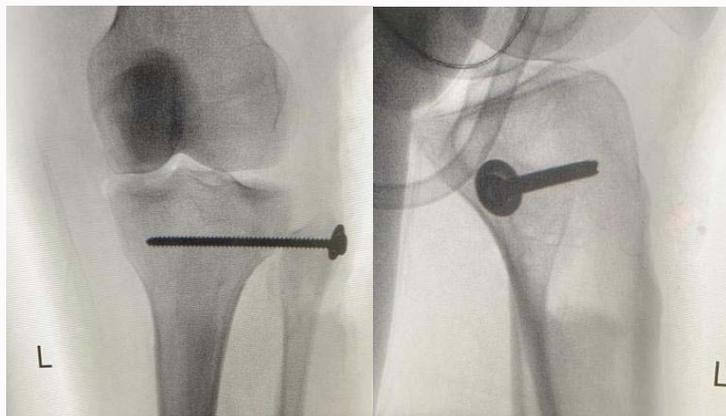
Intraoperative AP and lateral radiographs of knee.
